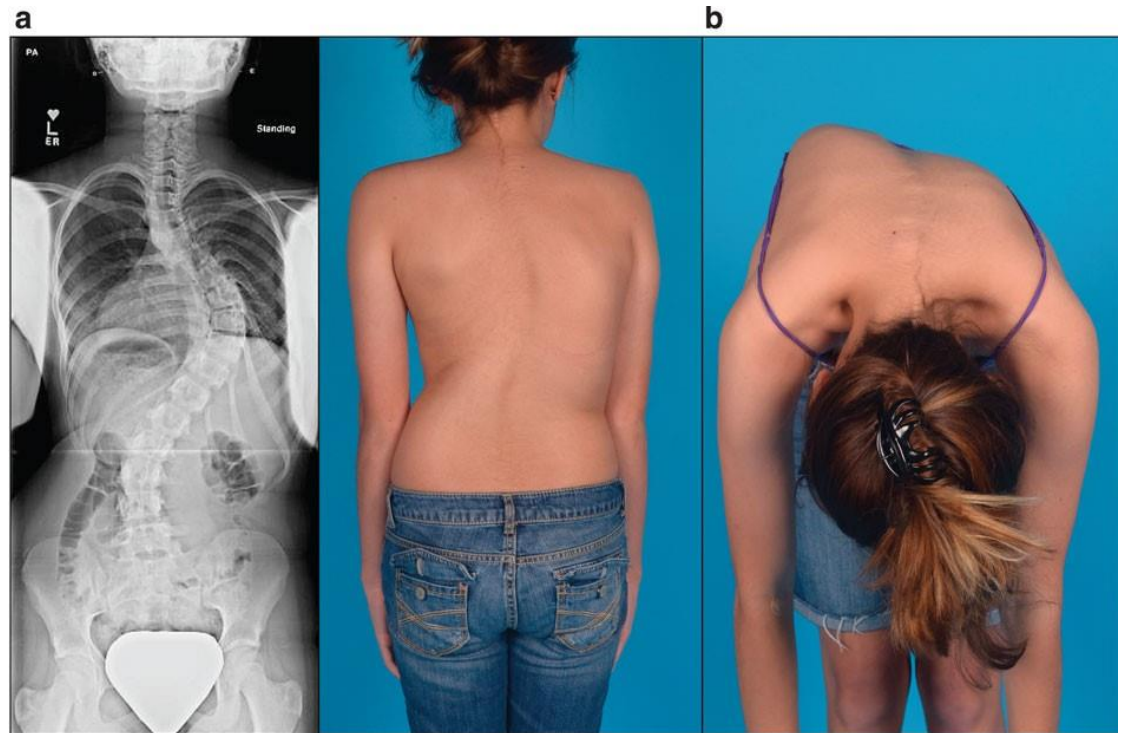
(a) Lateral radiograph image of prototypical right thoracic spinal curvature. Shoulder imbalance evident in clinical photograph. (b) Prominent rib hump evident with forward bending⁶
